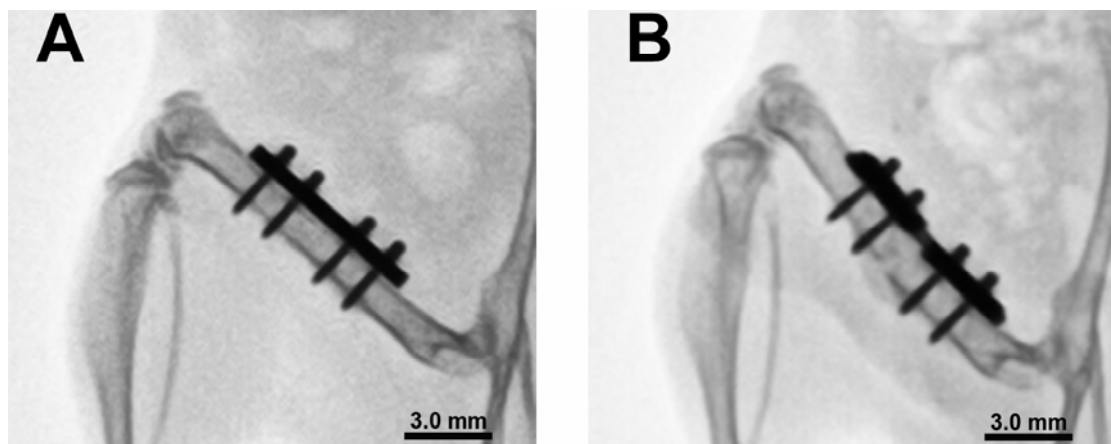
Radiographs (lateral view) exhibited hardly any callus on femora treated with the rigid fixator (day 21, a) but an abundant amount of callus was observed around fractures that were treated with the flexible fixator reaching a peak size around day 21 (b).
